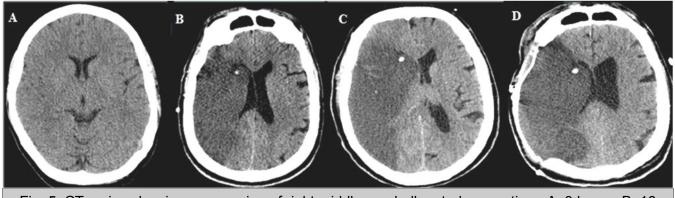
CT series showing progression of right middle cerebellar stroke over time: A: 3 hours, B: 16 hours, C: 24 hours, D: After decompressive craniectomy
